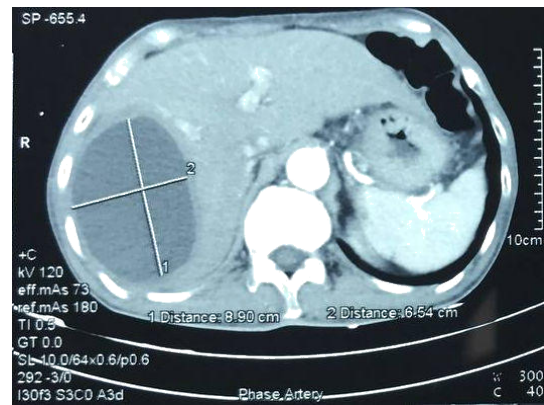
Axial View of Abdominal CT scan
